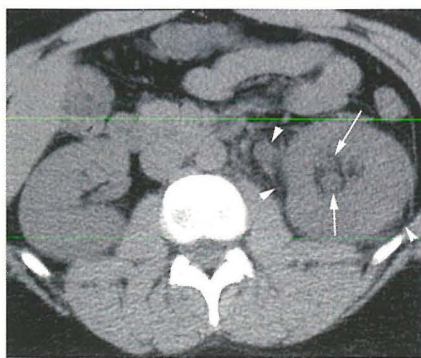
Axial CT scan shows stranding of the fat surrounding the left kidney and proximal left ureter (arrow heads). In addition, the left kidney is enlarged, with dilatation of the intrarenal collecting system (arrows).
